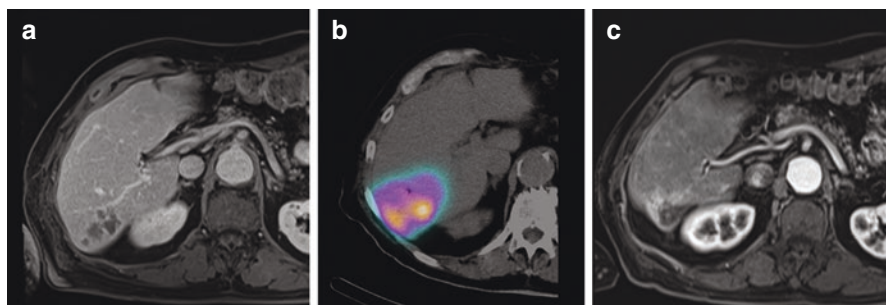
Superselective segmental radioembolisation or radiation segmentectomy. (a) CT scan before treatment showing a multinodular tumour in segment VI. (b) PET scan showing intense radiation in segment VI after superselective injection of Y90 resin microspheres into the segmental artery. (c) Significant atrophy of segment VI and lack of tumour activity 1 year after treatment
